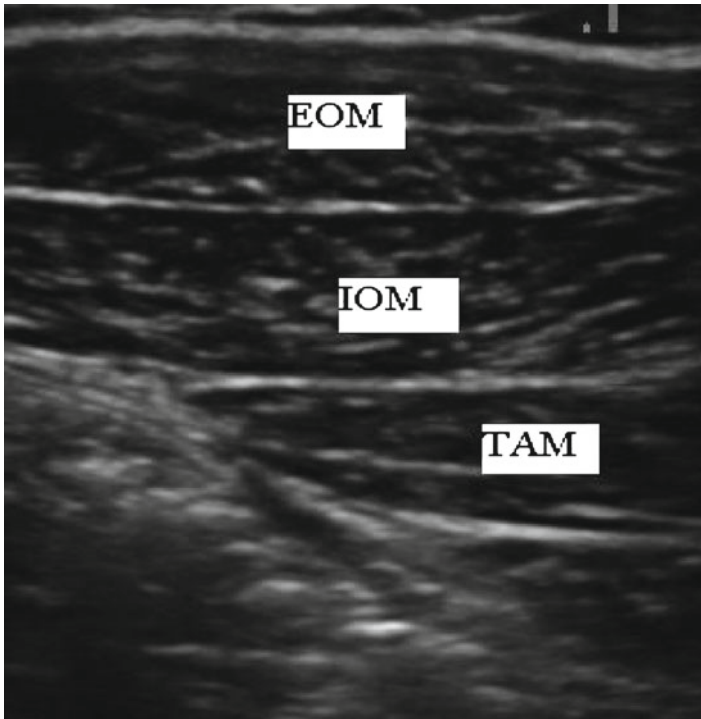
Ultrasound image showing the layers of abdominal muscles. *EOM* the external oblique muscle, *IOM* the internal oblique muscle, *TAM* the transverse abdominal muscle
